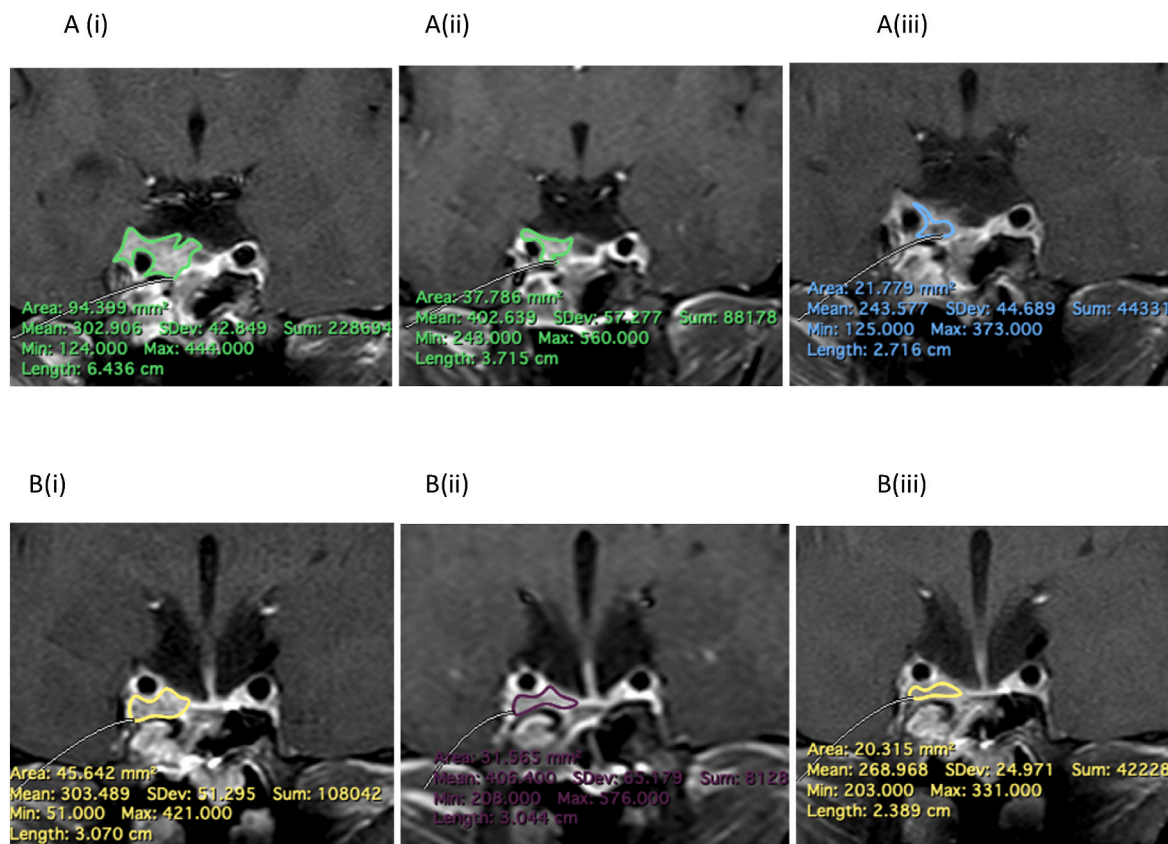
Representative MRI images showing the most shrinkage (A) Coronal contrasted T1-weighted MR images obtained at baseline (i) at 6-month (ii) & at 1-year of tamoxifen therapy (iii) (B) Coronal contrasted T1-weighted MR images obtained at baseline (i) at 6-month (ii) & at 1-year of tamoxifen therapy (iii).
